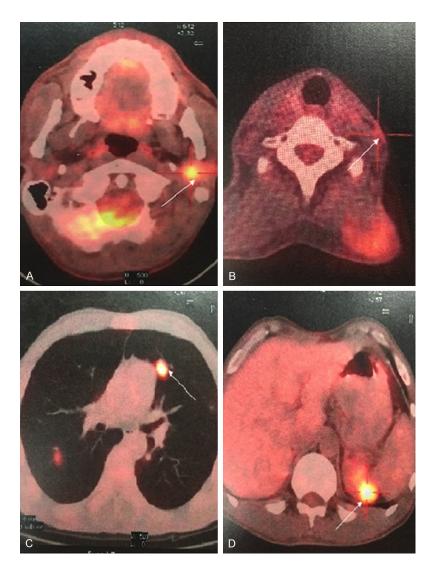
The results of PET/CT. F18 fluorodeoxyglucose positron emission tomography/computed tomography (PET/CT) shows recurrence of parotid gland carcinoma and metastases of left neck lymph node, lung, and adrenal gland. A. Metabolic activity (standardized uptake values of 5.4 g/ml) was observed in the left parotid gland region (arrow); B. Metabolic activity (standardized uptake values of 1.9 g/ml) was observed in the left neck lymph node region (arrow); C. Metabolic activity (standardized uptake values of 9.2 g/ml) was observed in the lung (arrow); D. Metabolic activity (standardized uptake values of 6.7 g/ml) was observed in the left adrenal (arrow).
